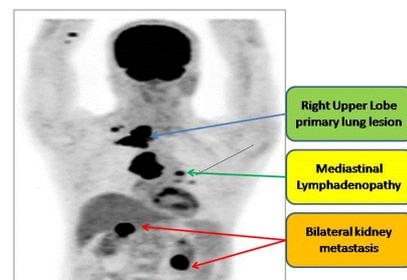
Baseline PET CT scan showing FDG avid right upper lobe lung lesions, mediastinal lymphadenopathy and bilateral kidney metastasis.
